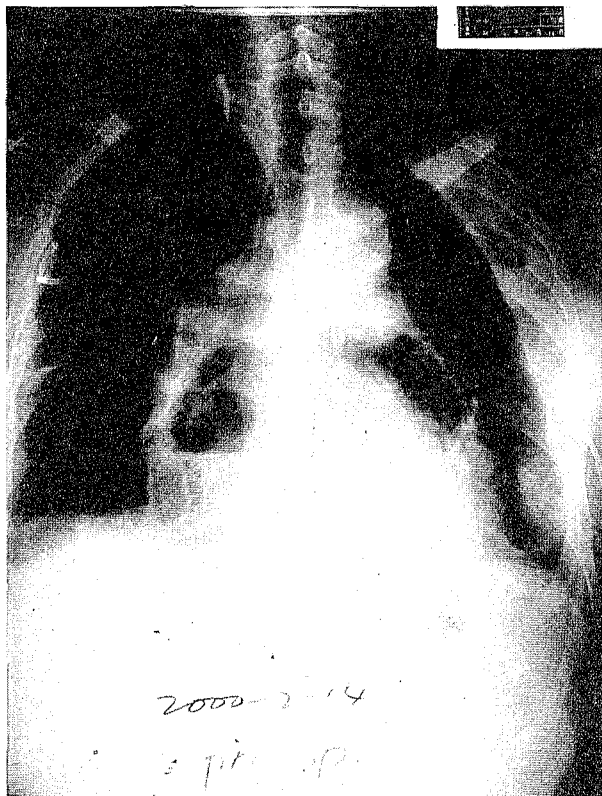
Chest roentgenogram in AP view shows a homogenous infiltration with a large air-fluid level in the mediastinum, multiple insertions of small bore chest tubes, and a central venous catheter
